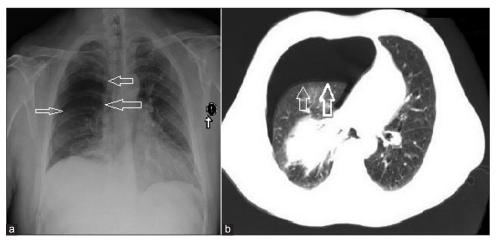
(a) Chest radiograph showing large right-sided pneumothorax (arrows); (b) Chest CT showing large right-sided pneumothorax with left mediastinal shift (arrows)
